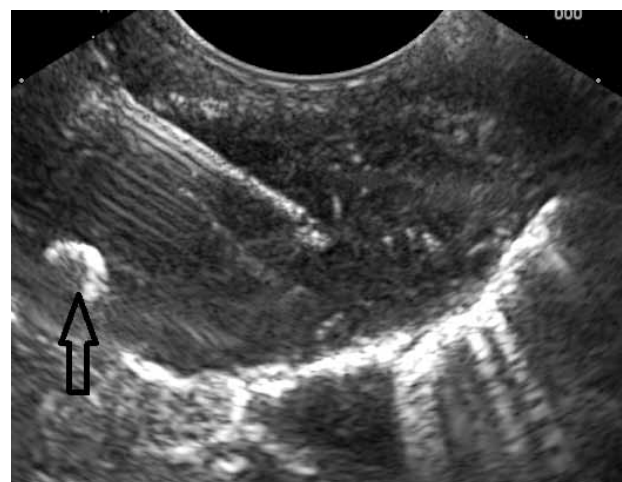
Endoscopic ultrasound-guided fine needle aspiration cytology being performed from the subcarinal lymph node. Large hyperechoic foci noted (arrow)
